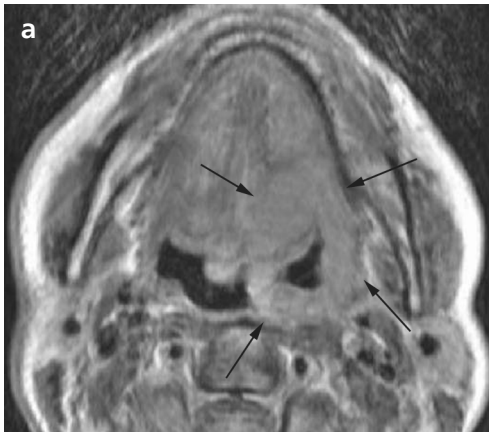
Example of grade 0 posttreatment MRI. (a) Contrast enhanced, pretreatment MRI image (T1-weighted) at tongue base level showing an advanced primary oropharyngeal tumor extending to the lateral and posterior pharyngeal wall (arrows). (b) Contrast-enhanced, posttreatment MRI image (T1-weighted) of the same patient at the same level as figure 1a, showing no detectable focal abnormalities, which was graded 0. Biopsies taken 8 weeks after treatment were negative. The patient remained disease free during a 5-year follow-up period.
